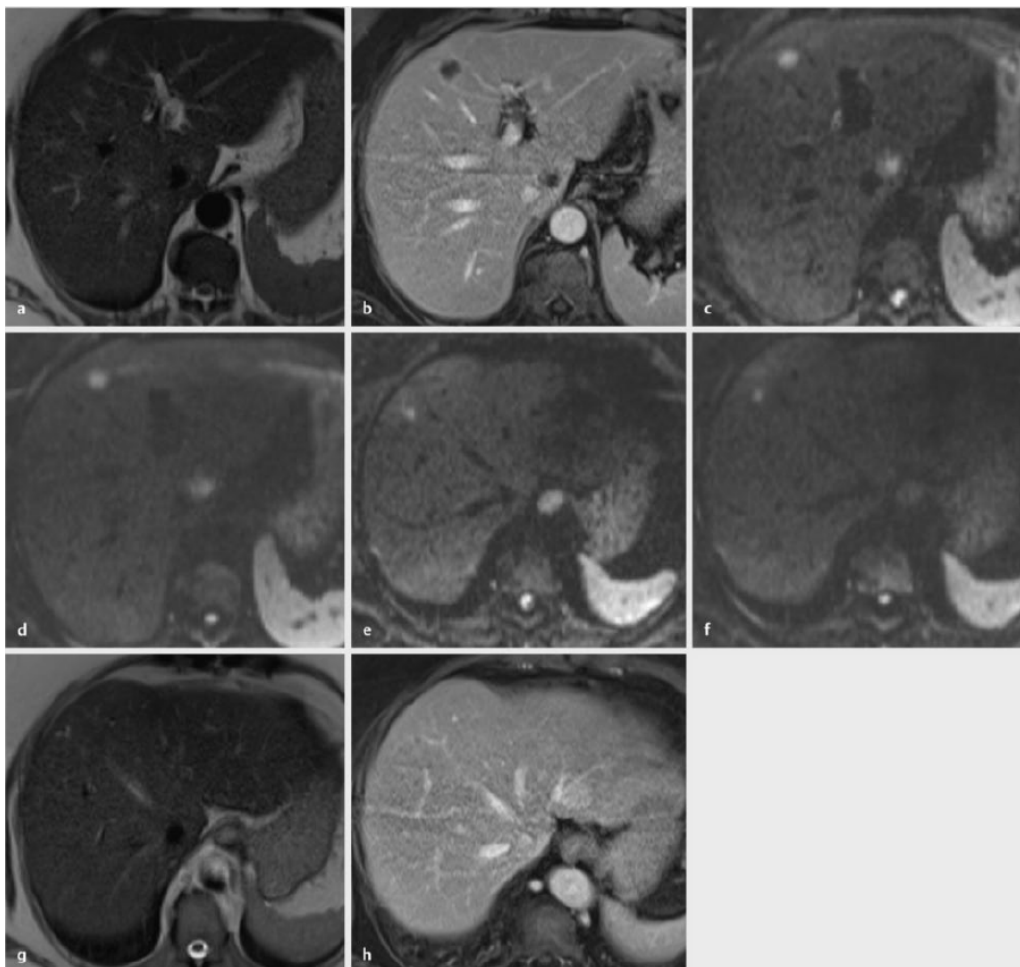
53-year-old patient with hepatic metastases from colon carcinoma before planned partial liver resection. a: in the axial T2-HASTE sequence, flat hyperintense lesions are seen in S4a and S1; b: the lesions present centrally hypointense with annular peripheral enhancement in the portal venous phase after contrast administration (ax T1-VIBE); c: in DWI, both lesions are hyperintense at $b = 50 \text{ s/mm}^2$; d: even at $b = 600 \text{ s/mm}^2$, both lesions are hyperintense, indicating restricted diffusion; e: in DWI, another smallest lesion is detectable in S8, which is hyperintense at $b = 50 \text{ s/mm}^2$; f: detection of hyperintense lesion in S8 at $b = 600 \text{ s/mm}^2$; g: the lesion cannot be reliably delineated in T2 weighting; h: the lesion cannot be reliably demarcated even after contrast administration.
